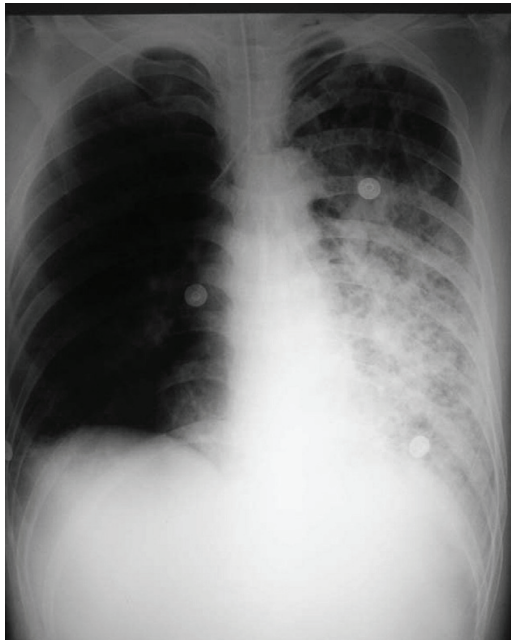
Chest radiograph showed unilateral involvement of the lung with increased infiltrates and patchy consolidation with apical lung spared.
